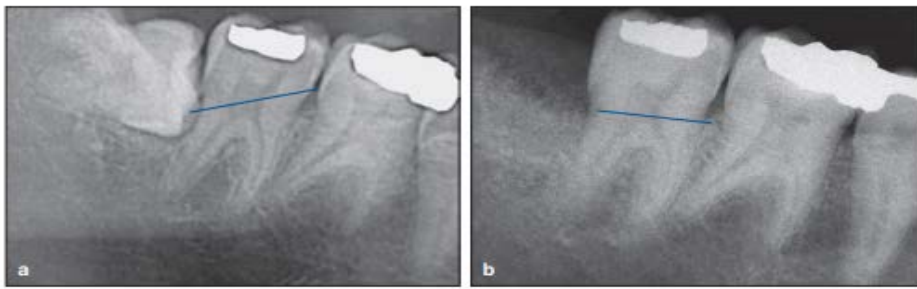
(a) Radiograph demonstrating a third molar in close proximity to the distal roots of a second molar. The third molar was extracted, and the SDG procedure was used to graft the extraction site. (b) Radiograph of the alveolar bone and regained bone tissues distal to the second molar 3 months after surgery. (Case performed by Dr Nardi Casap-Caspi.)
